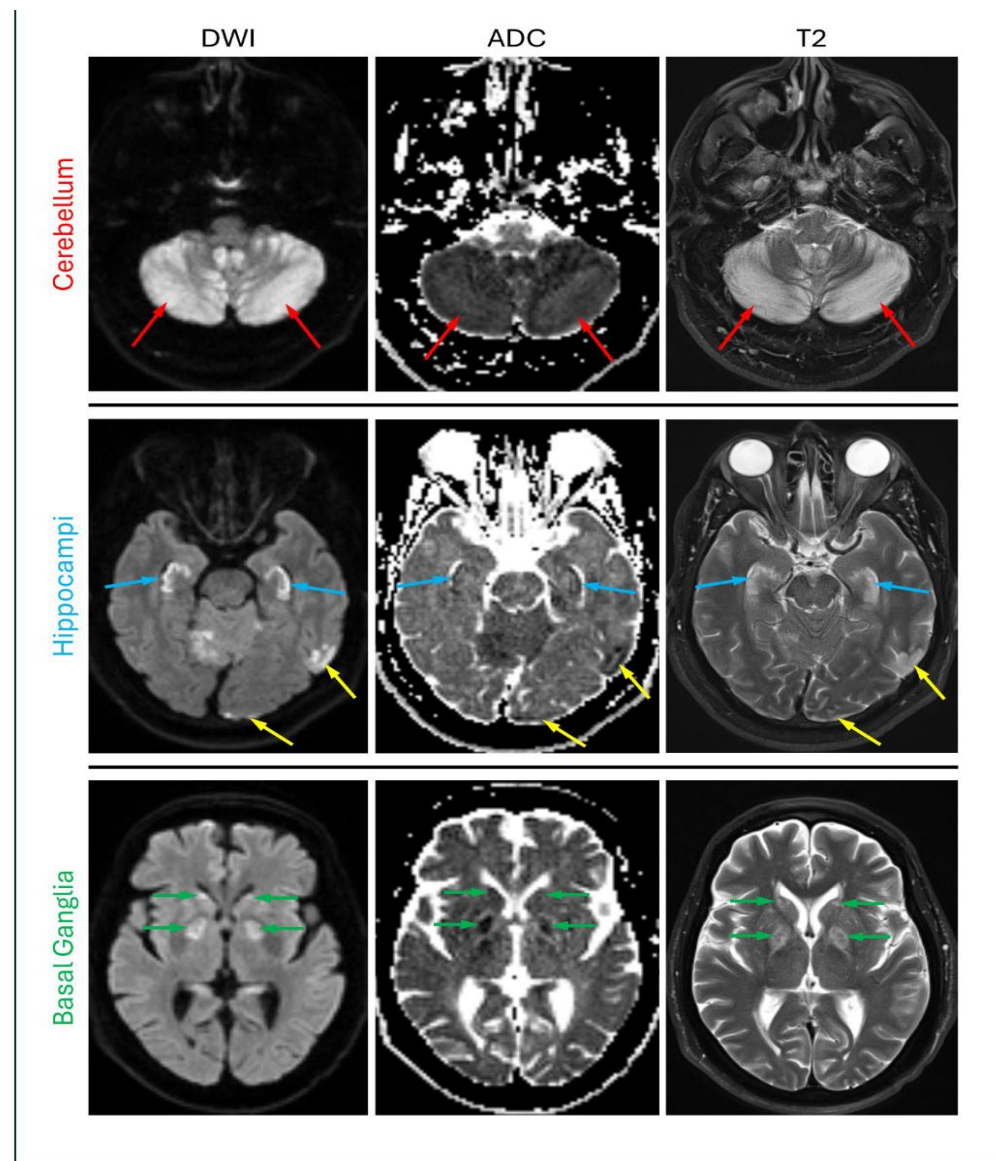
MRI case example of CHANTER syndrome in a 58-year-old male patient with representative DWI, ADC, and T2 axial images. Areas of restricted diffusion and T2 signal hyperintensity are demonstrated in the cerebellum (red arrows), hippocampi (blue arrows), and basal ganglia (green arrows). In addition, there are areas of similar signal abnormality involving the posterior left cerebral cortex (yellow arrows).
